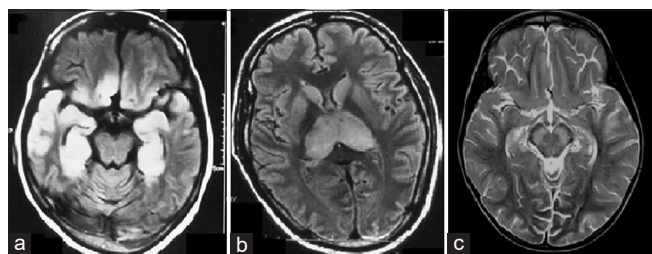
Cranial MRI changes in herpes simplex encephalitis and Japanese encephalitis. (a) FLAIR sequence shows bilateral temporal lobe and right basi-frontal hyper intensity in a patient with herpes simplex encephalitis. (b) FLAIR sequence in a patient with Japanese encephalitis shows bilateral thalamic and basal ganglia involvement. (c) FLAIR sequence axial section of a patient with West Nile encephalitis showing the involvement of substantia nigra
